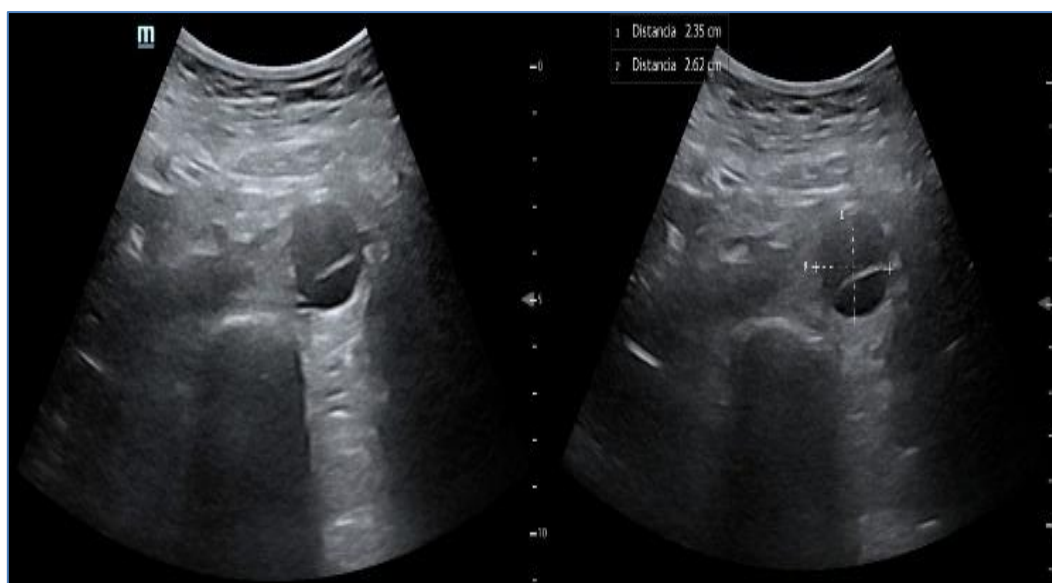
Point-of-Care Ultrasound (Pocus) Showing a Transverse (Axial) View of the Descending Aorta with an Intraluminal Intimal Flap; Maximal Diameter 2.6 Cm.
